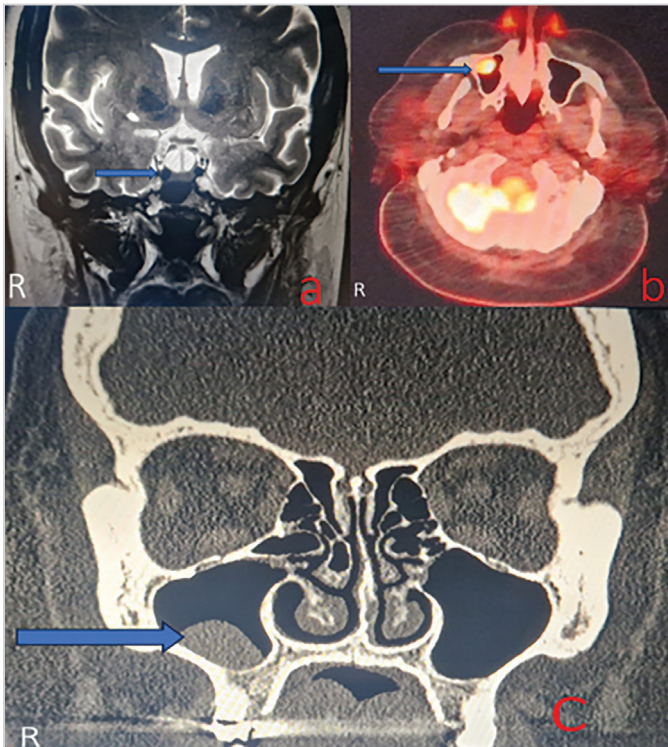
a) Coronal MRI of the pituitary with gadolinium shows a partially empty sella and a small non-enhancing focus in the right anterior pituitary (blue arrow), b) The blue arrow highlights a rounded polypoid lesion arising from the anterior wall of the right maxillary antrum, demonstrating marked FDG uptake (SUV_{max} 11.9), c) Coronal CT reveals a well-defined low-density lesion at the base of the right maxillary antrum (blue arrow)
